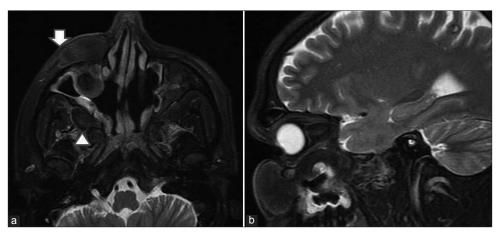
Fat-suppressed T2-weighted axial (a) and sagittal (b) images show hypointense lesion in right premaxillary region, extending into infraorbital foramen (short arrow), floor of orbit, and into pterygopalatine fossa (arrowhead)
